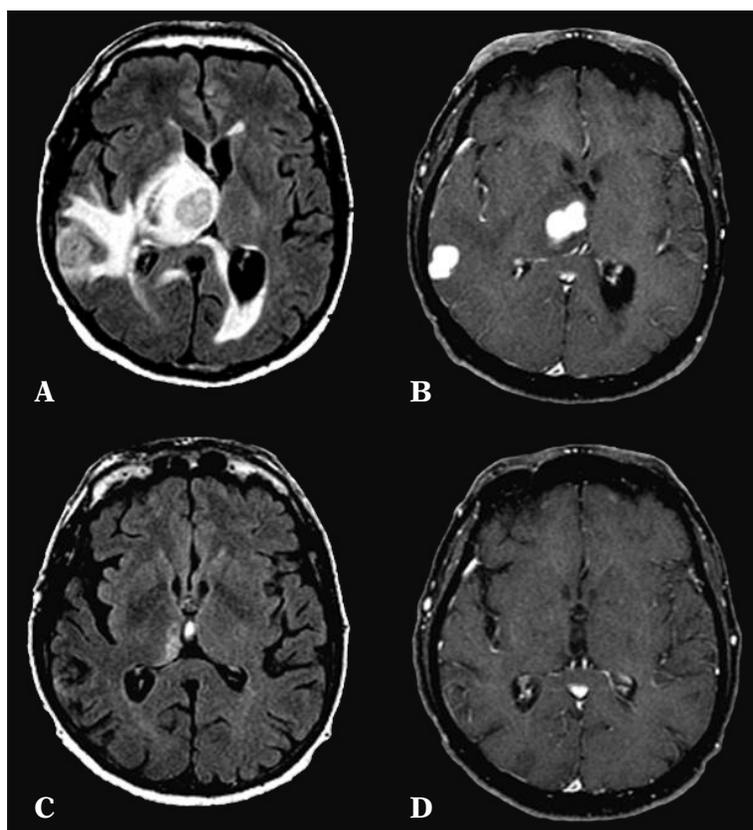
Case report 2: (A) fluid-attenuated inversion recovery (FLAIR) MRI image showing hyperintense non caseous nodules with surrounding edema in the right temporal lobe and thalamus, (B) homogeneous contrast enhancement on T1 MRI. MRI images three months later with anti-TB treatment without corticosteroids: (C) minimal edema, (D) absence of contrast enhancement.
